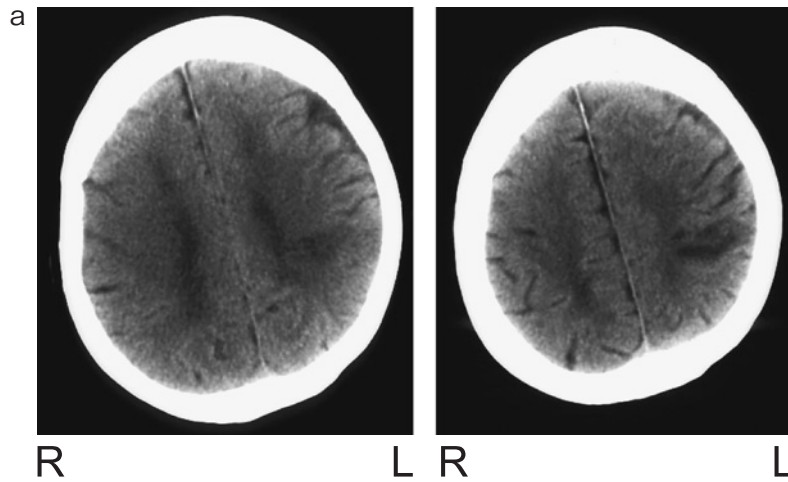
Computed tomography of the brain on the first hospital day: Cerebral infarction was identified in the left angular gyrus.
